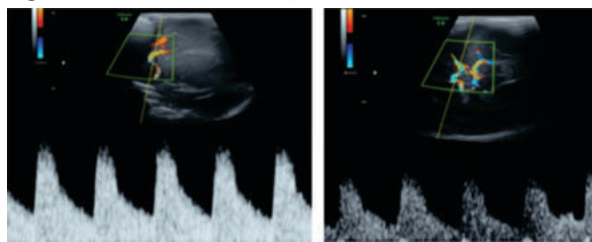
The ACA and MCA were visualized using color Doppler through the anterior fontanel; ACA was seen in the midline sagittal plane and blood flow velocity was determined at the proximal portion of it at its curve around the corpus callosum. The MCA was seen in the coronal or sagittal plane.
